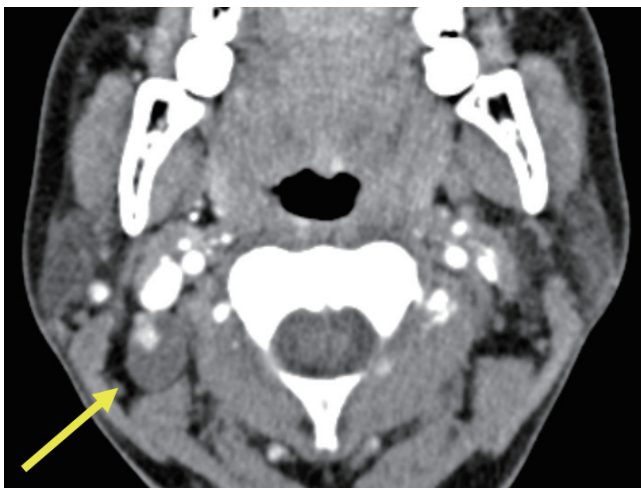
Axial computed tomography scan shows a lymph node with cystic change with an eccentric strong enhancing solid portion that gives the lymph node a heterogeneous enhancement pattern (arrow). No normal hilar structure can be seen. This lymph node would be classified into a suspicious category according to K-TIRADS. K-TIRADS = Korean Thyroid Imaging Reporting and Data System.
